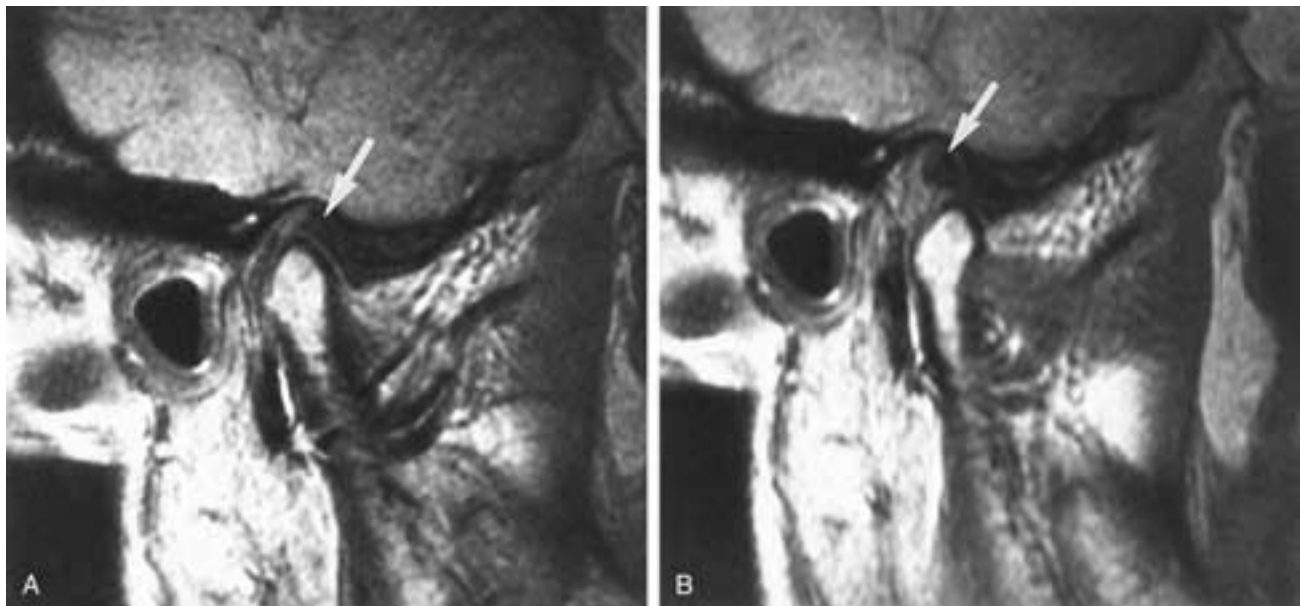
Stuck disk. Sagittal proton density MR images with a closed mouth (A) and maximal mouth opening (B) in a patient with limitation of mouth opening. The disk (*arrow*) is located in the normal superior position with a closed mouth. On opening, the disk does not move out of the glenoid fossa and the condyle does not translate all the way down to the articular eminence. This is consistent with a stuck disk condition.
